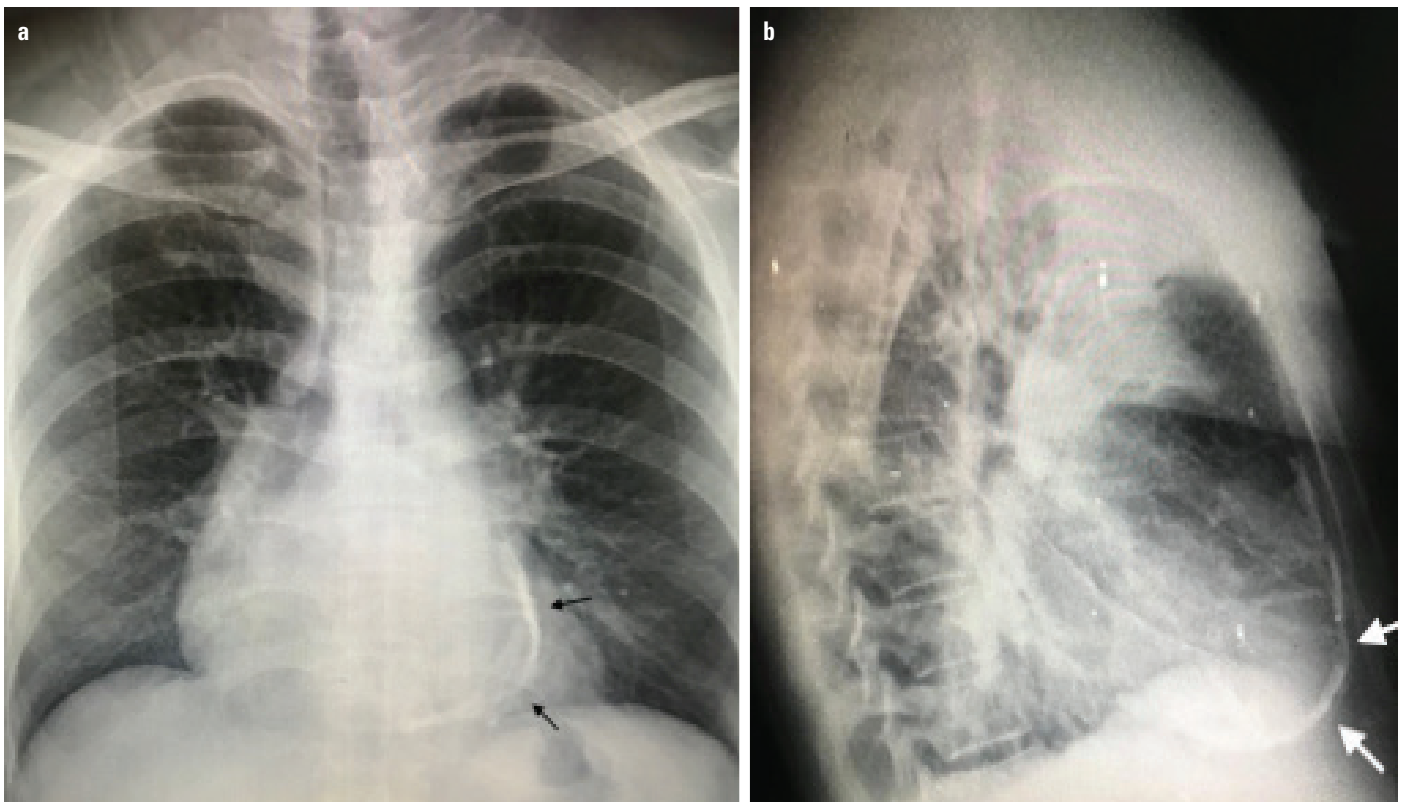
(a) Chest x-ray image showing a calcified pericardial thickening (black arrows) surrounding the ventricular wall. (b) Lateral x-ray of the chest showing the calcified pericardium (white arrows)
